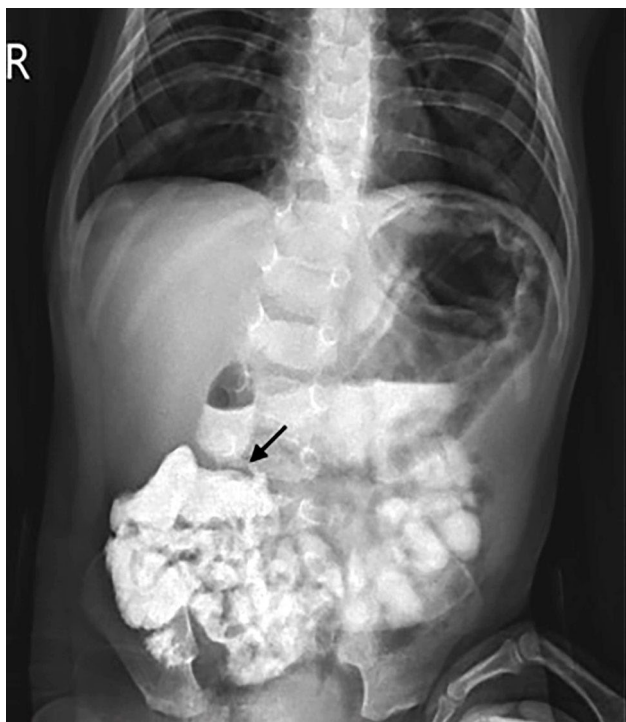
Oral contrast-enhanced upper gastrointestinal radiograph showing a transition point in the duodenum, marked by an arrow, where the lumen narrows due to obstruction.
